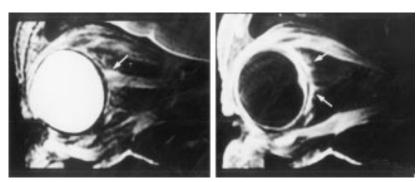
Sagittal T2 weighted magnetic resonance imaging scan (left) shows a high signal intensity area in the optic nerve sheath and adjacent posterior sclera (arrow). Sagittal post gadolinium-DTPA T1 weighted imaging scan using a fat suppression technique (right) shows enhancement effects around the posterior sclera and the optic nerve sheath (arrows).
